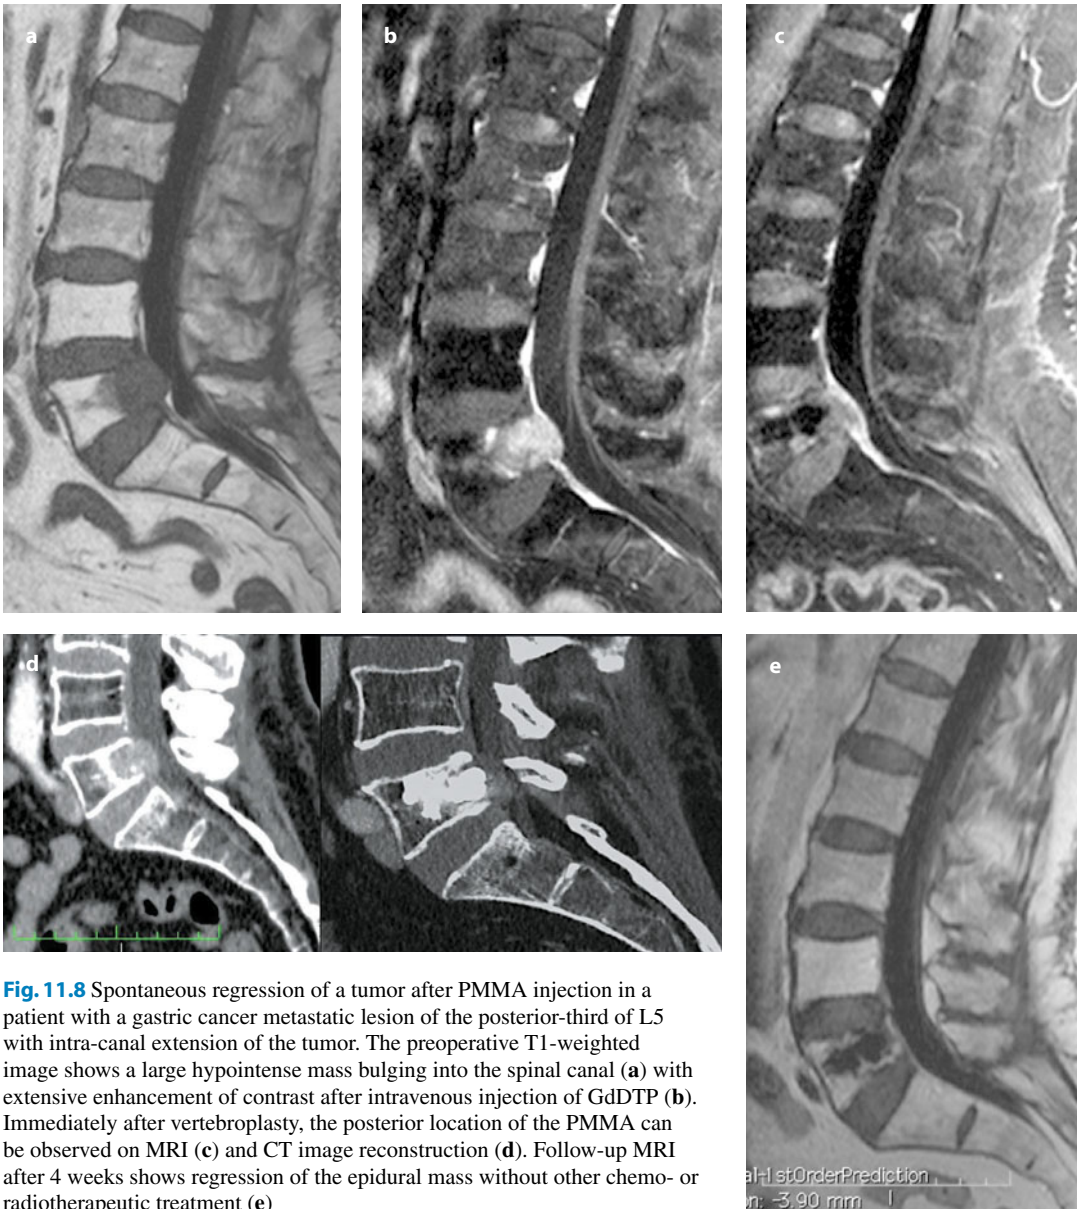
Spontaneous regression of a tumor after PMMA injection in a patient with a gastric cancer metastatic lesion of the posterior-third of L5 with intra-canal extension of the tumor. The preoperative T1-weighted image shows a large hypointense mass bulging into the spinal canal (a) with extensive enhancement of contrast after intravenous injection of GdDTP (b). Immediately after vertebroplasty, the posterior location of the PMMA can be observed on MRI (c) and CT image reconstruction (d). Follow-up MRI after 4 weeks shows regression of the epidural mass without other chemo- or radiotherapeutic treatment (e)
